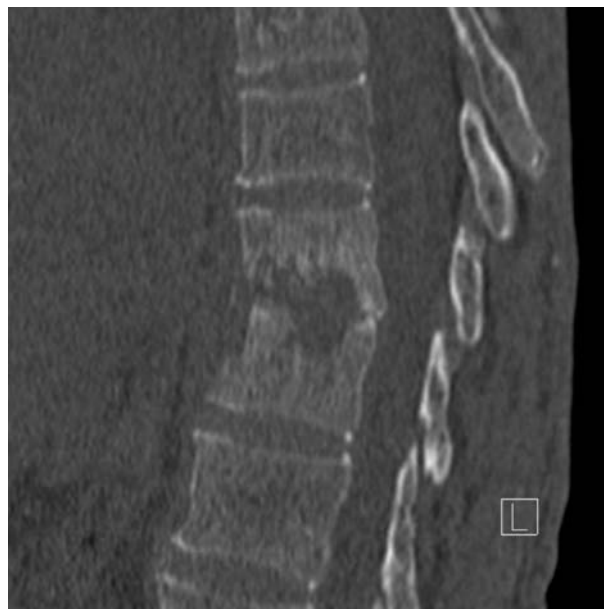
A lateral view of a spiral CT scan of the lower thoracic spine showing infective discitis at the T9/10 level with destruction of the vertebral endplates above and below.
